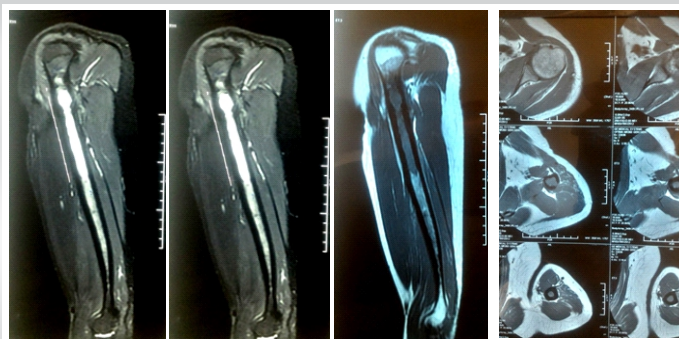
Post-neoadjuvant chemotherapy magnetic resonance imaging demonstrating complete regression of the soft tissue extension with no residual extraosseous tumor mass.
